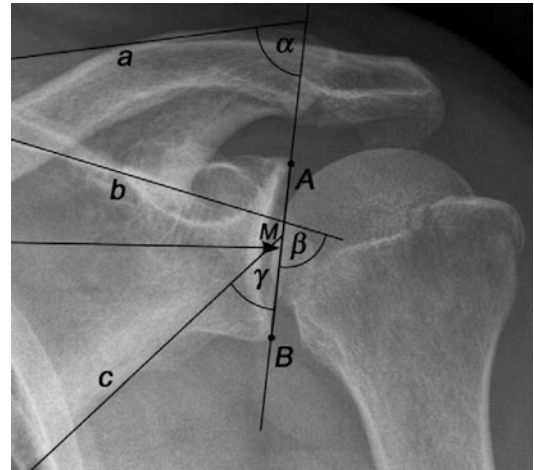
Measurement of glenoid inclination on radiographs. The measurement of glenoid inclination relative to the scapula in an AP radiograph was defined by Maurer et al. The glenoid fossa line (AB) connects the superior and inferior rims of the glenoid. Angle α is between the spine of the scapula (line a) and glenoid fossa line (AB). Angle β is between the floor of the supraspinatus fossa (line b) and the glenoid fossa line (AB). Angle γ is between the lateral margin of the scapula (line c) and the glenoid fossa line (AB). (Adapted from Maurer et al. [22])
